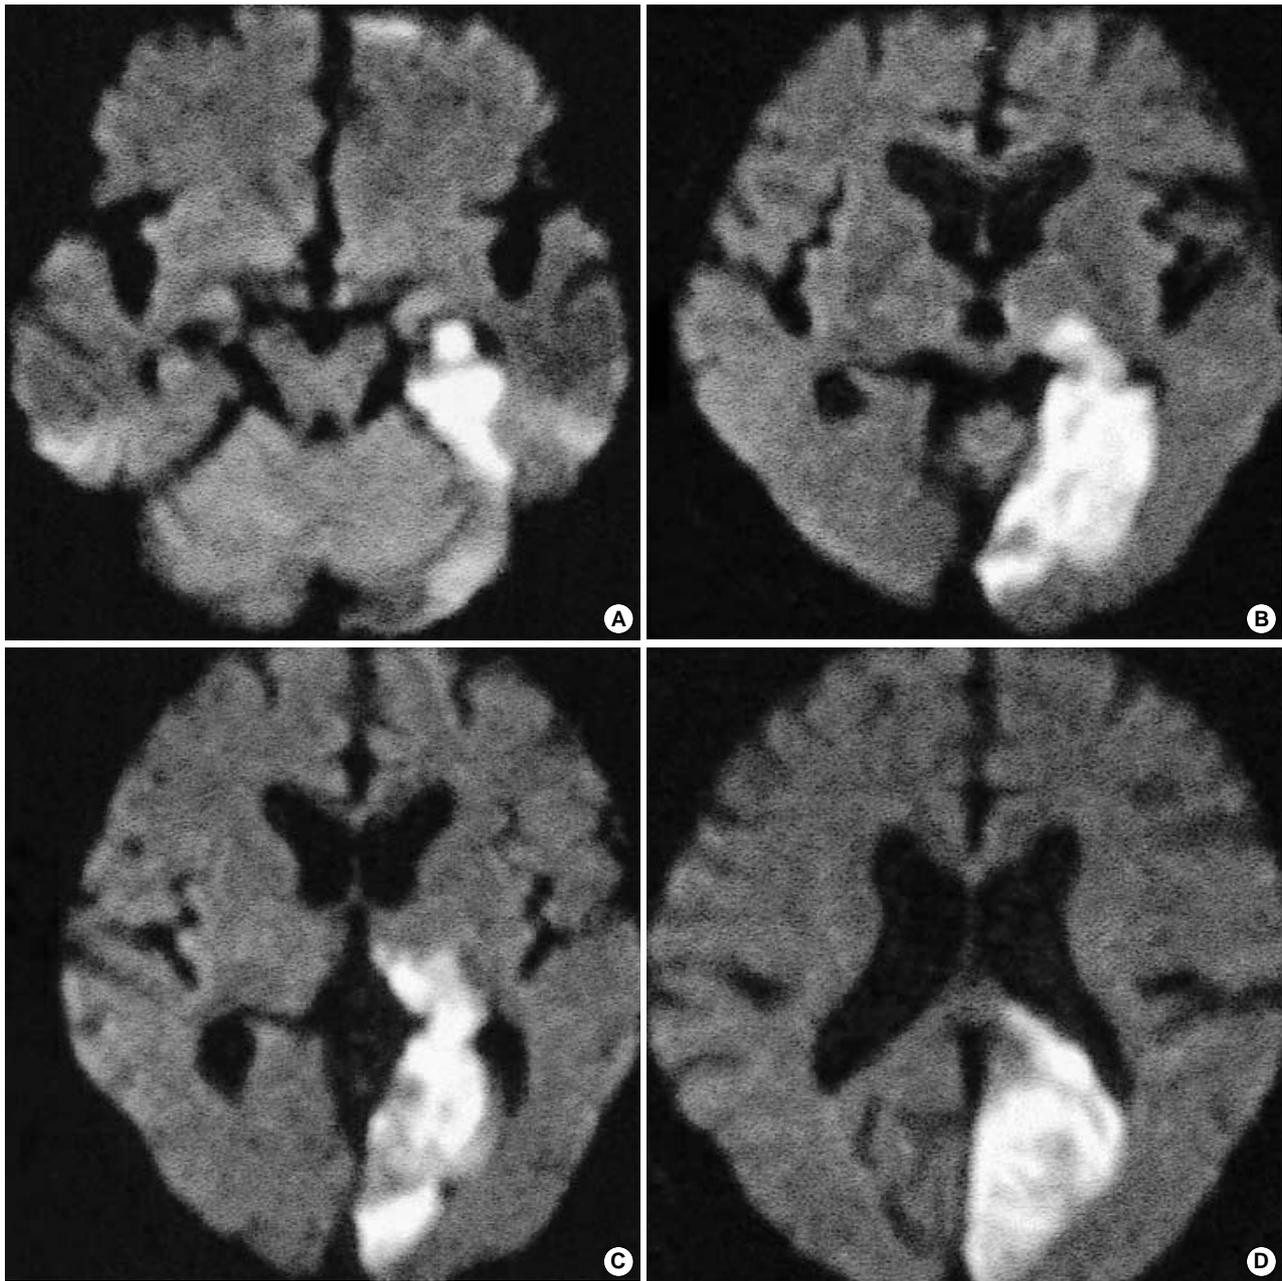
Diffusion-weighted axial MRI showing acute infarction in the posterior cerebral arterial territory. Increased signal intensities are seen in amygdala and hippocampus (A), geniculate bodies and temporal cortex (B), pulvinar, dorsomedial thalamus and occipital cortex (C), splenium and occipital cortex (D).
